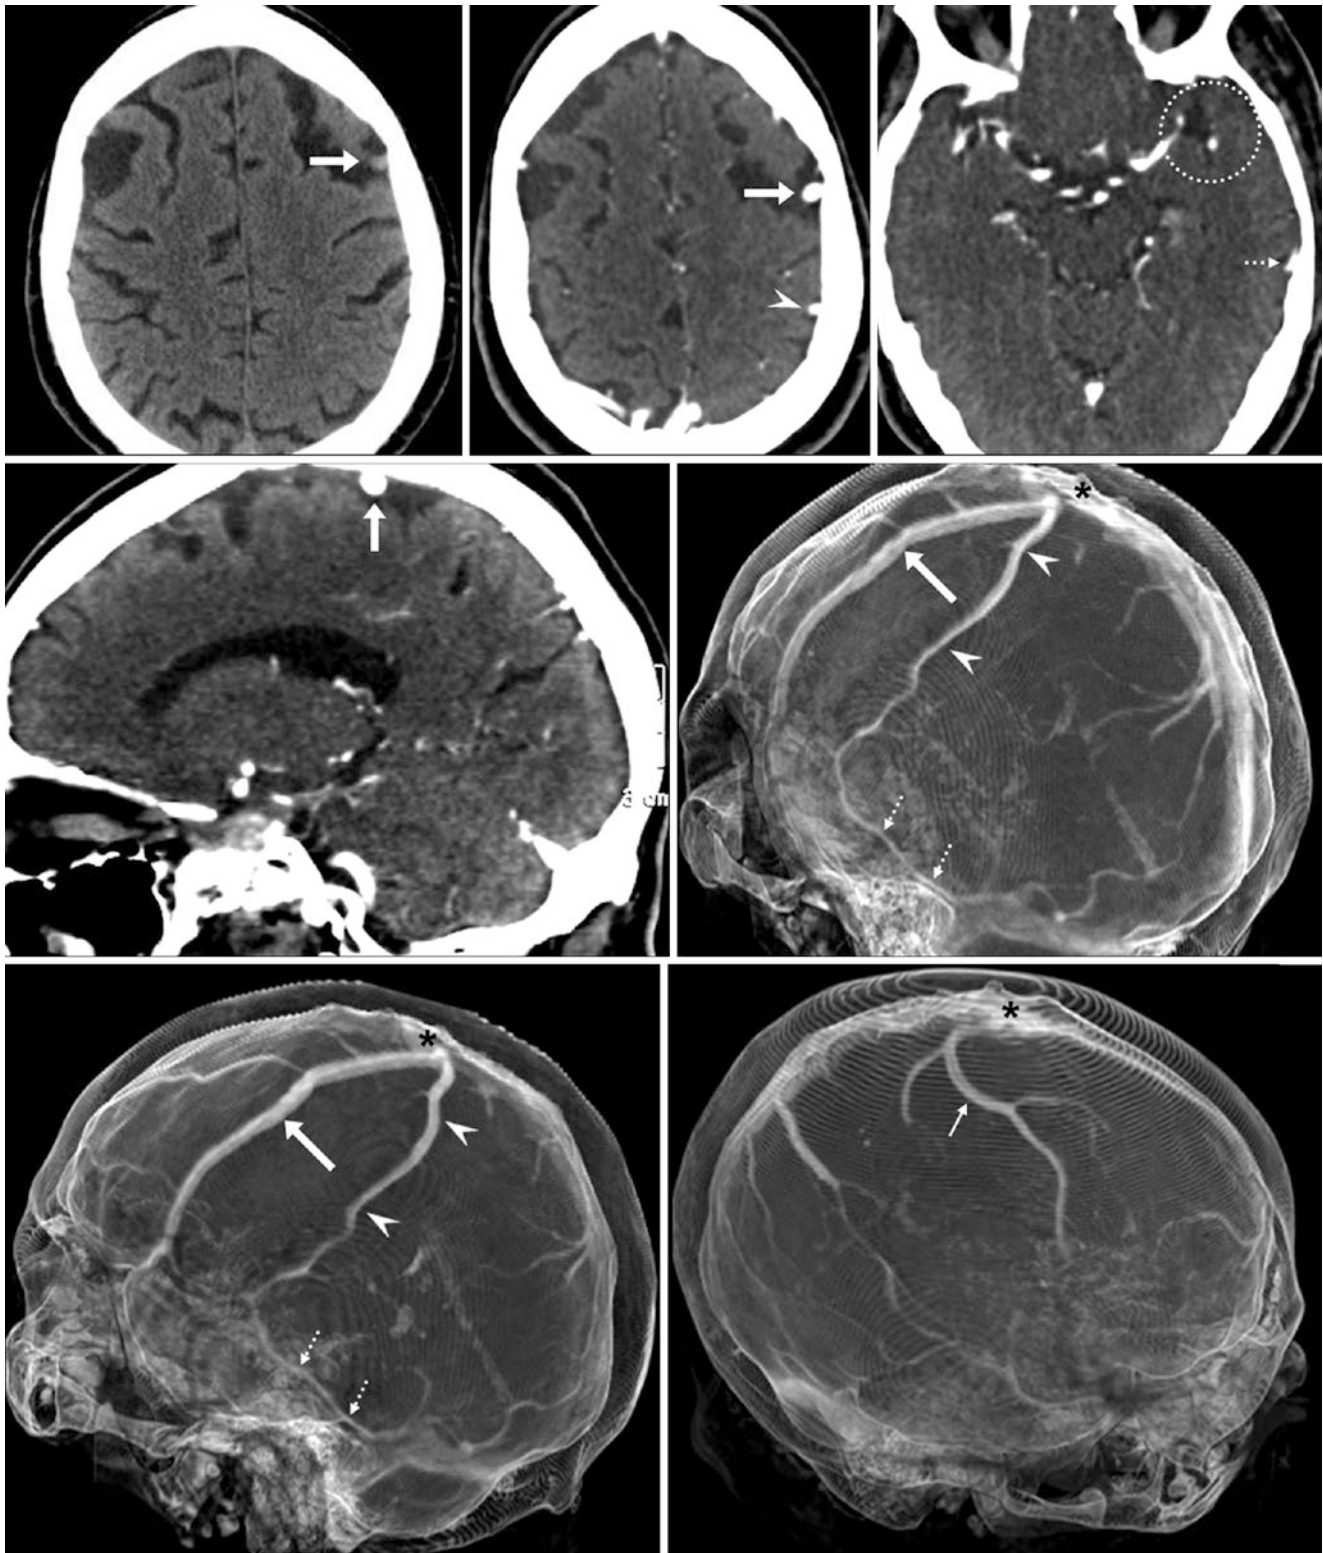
67-year-old with memory loss. *Top row:* A prominent vascular structure (*arrows*) was initially noted within the left superior frontal sulcus on a nonenhanced CT (*left*). A CTV with axial images (*middle* and *right*) confirmed this to be an early bifurcation of a dominant VOT, where an enlarged cortical vein (*arrows*) arose early from the VOT (*arrowheads*). *Middle row:* On a CTV, a sagittal MPR (*left*) and an LPO
